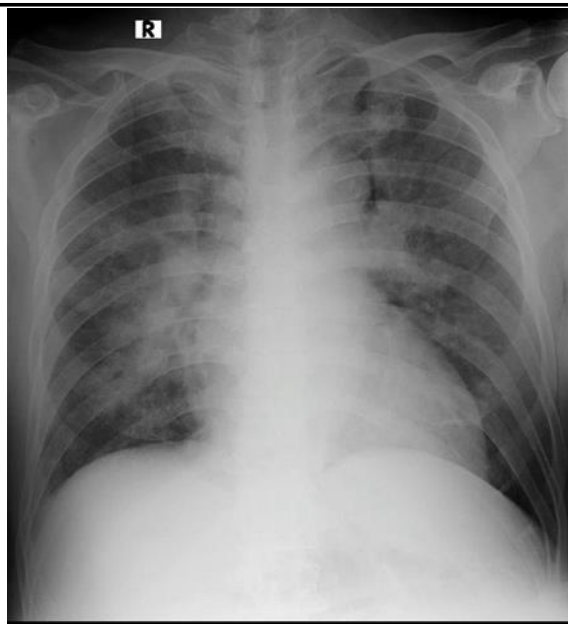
Chest x-ray during hospital admission on 11 January 2022 (showed alveolar pulmonary edema, suspected bacterial bilateral pneumonia, cardiomegaly with LVH)
